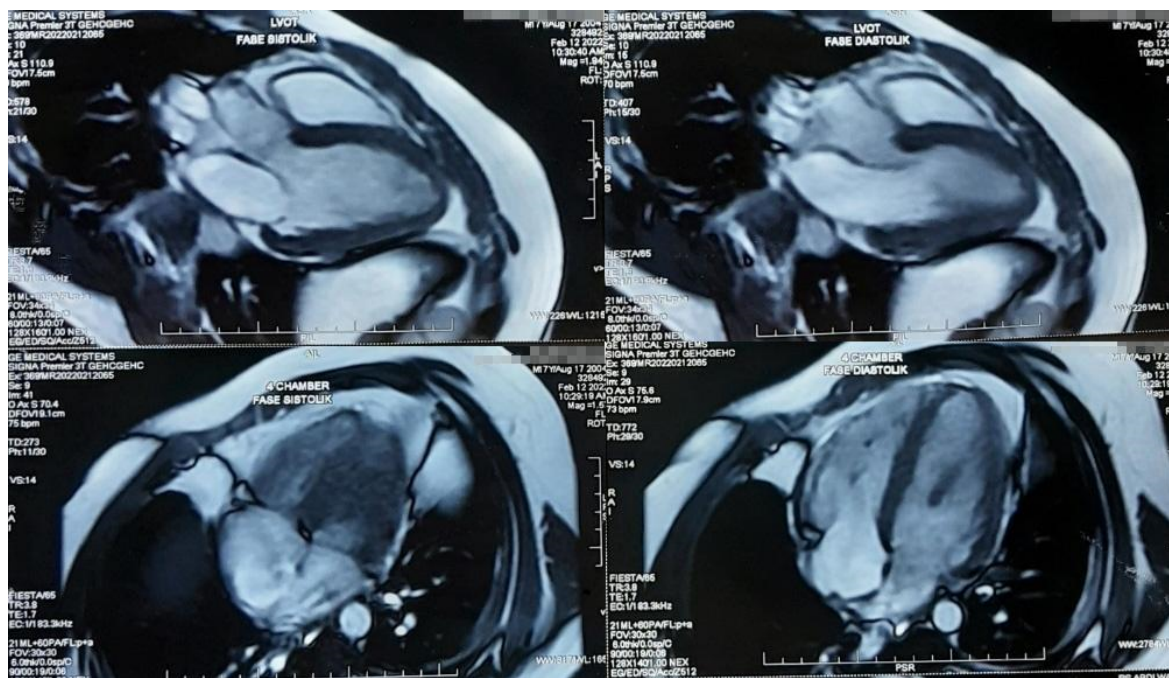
Cardiac MRI show hyperintensity of the mid myocardium in lateral wall of left.
